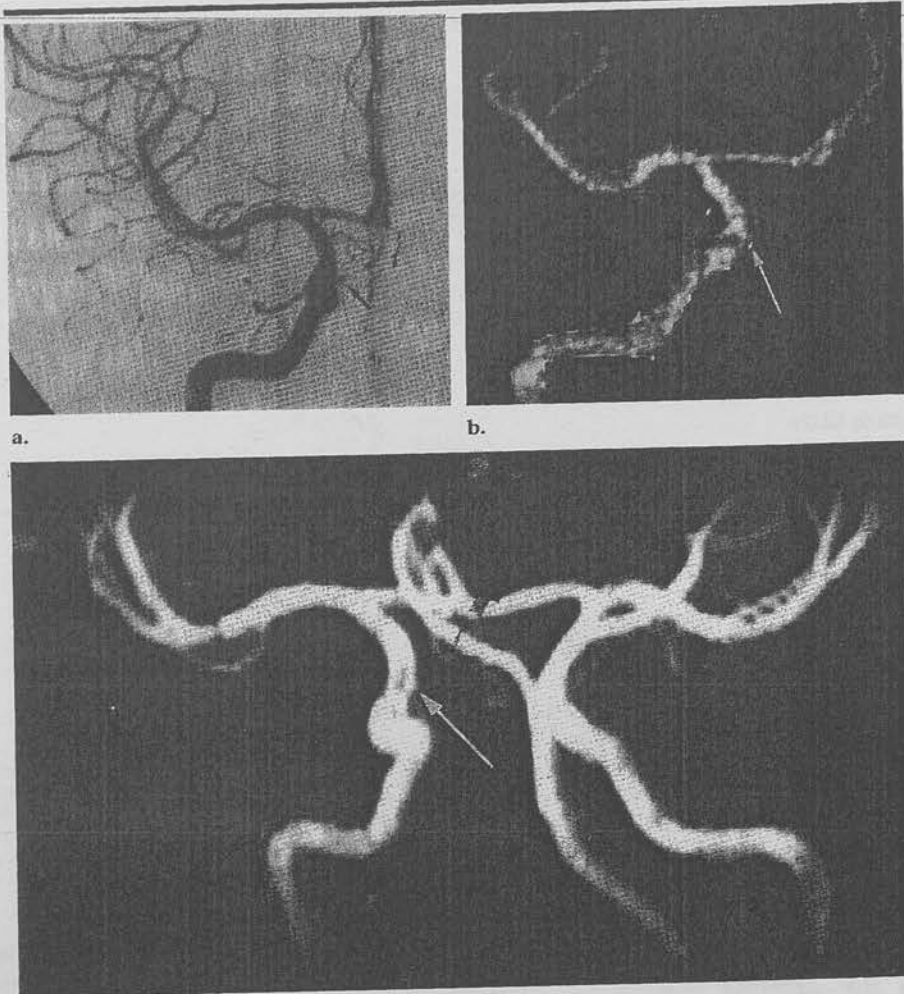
(a) Cranial anteroposterior 15° intraarterial DSA image shows a 2-mm aneurysm (arrow) of the right intracavernous carotid artery. (b) On the targeted maximum intensity projection CT angiogram, obtained in the same patient, at an angle comparable to that in a, the site of the 2-mm aneurysm of the right intracavernous carotid artery is indicated (arrow), but the aneurysm cannot be readily appreciated. (c) On the collapsed maximum intensity projection MR angiogram in the coronal plane (three-dimensional time-of-flight, 43/8, 20° flip angle, 20-cm field of view, one signal acquired, 256 × 512 matrix, acquisition time of 11 minutes 48 seconds), similar to findings in b, the site of the 2-mm aneurysm of the right intracavernous carotid artery is indicated (arrow), but the aneurysm cannot be readily appreciated.
